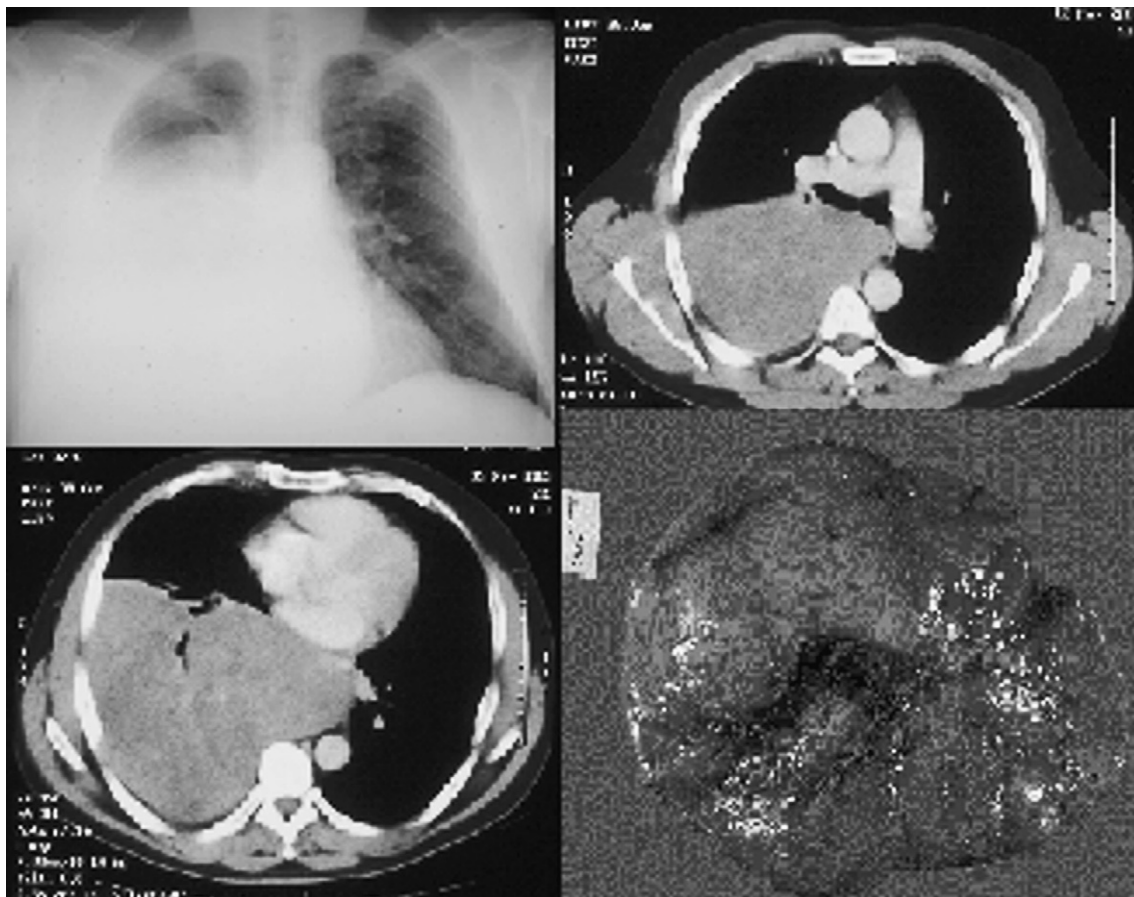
Chest roentgenogram (top left). Computed tomogram revealing a broad-based mass on the parietal pleura (top right and bottom left). Gross morphologic image of the mass (bottom right).
